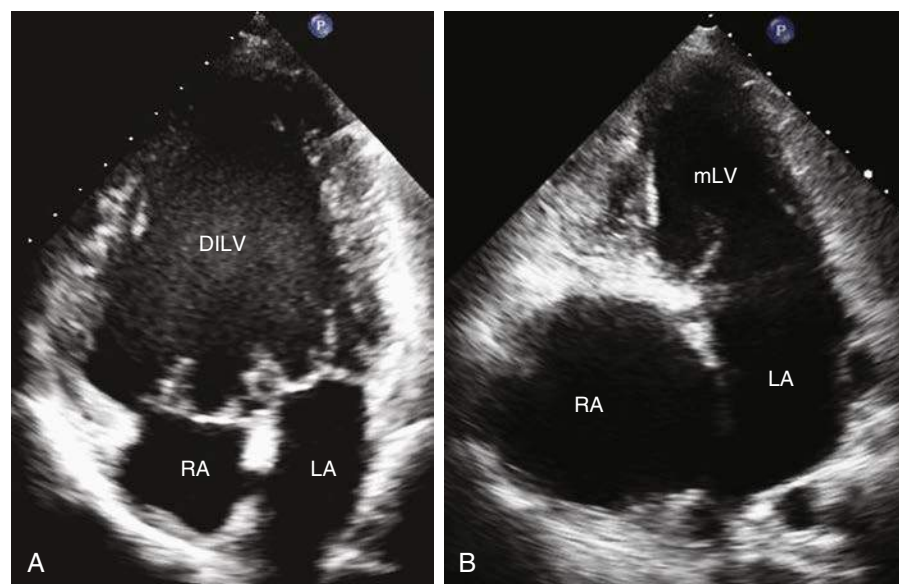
Transthoracic echocardiography two-dimensional imaging from a patient with a univentricular heart. A, Double-inlet left ventricle. B, Absent right atrioventricular connection. DILV, Double inlet left ventricle; LA, left atrium; mLV, morphologic left ventricle; RA, right atrium.
